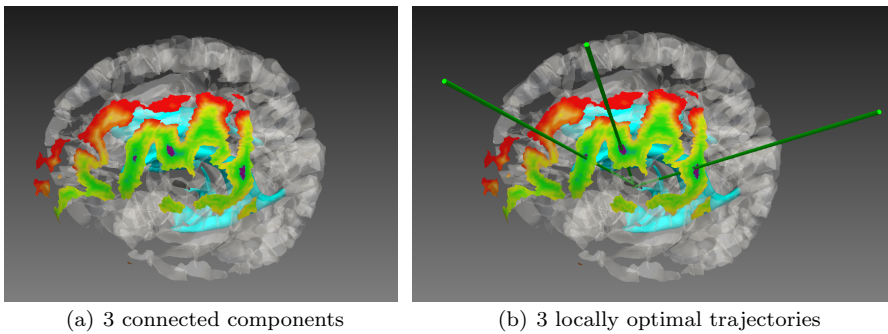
Snapshots showing a typical 3D scene with the result of a resolution process, displayed as a color map where the best entry points are in green and the worst in red. In (a) three connected components, representing valleys of locally minimal values of f are displayed in purple. Corresponding locally optimal trajectories are displayed as green cylinders in (b). In both images, the target is in black, the ventricles in blue, and the sulci are white and semi-transparent for readability purposes. The MRI is not shown on these pictures. Complete 3D scene for this patient can be seen in Fig. 2
